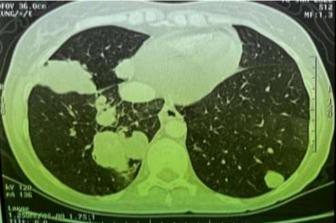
Chest CT scan showing pulmonary lesions suggesting a secondary location of the uterine tumour.
